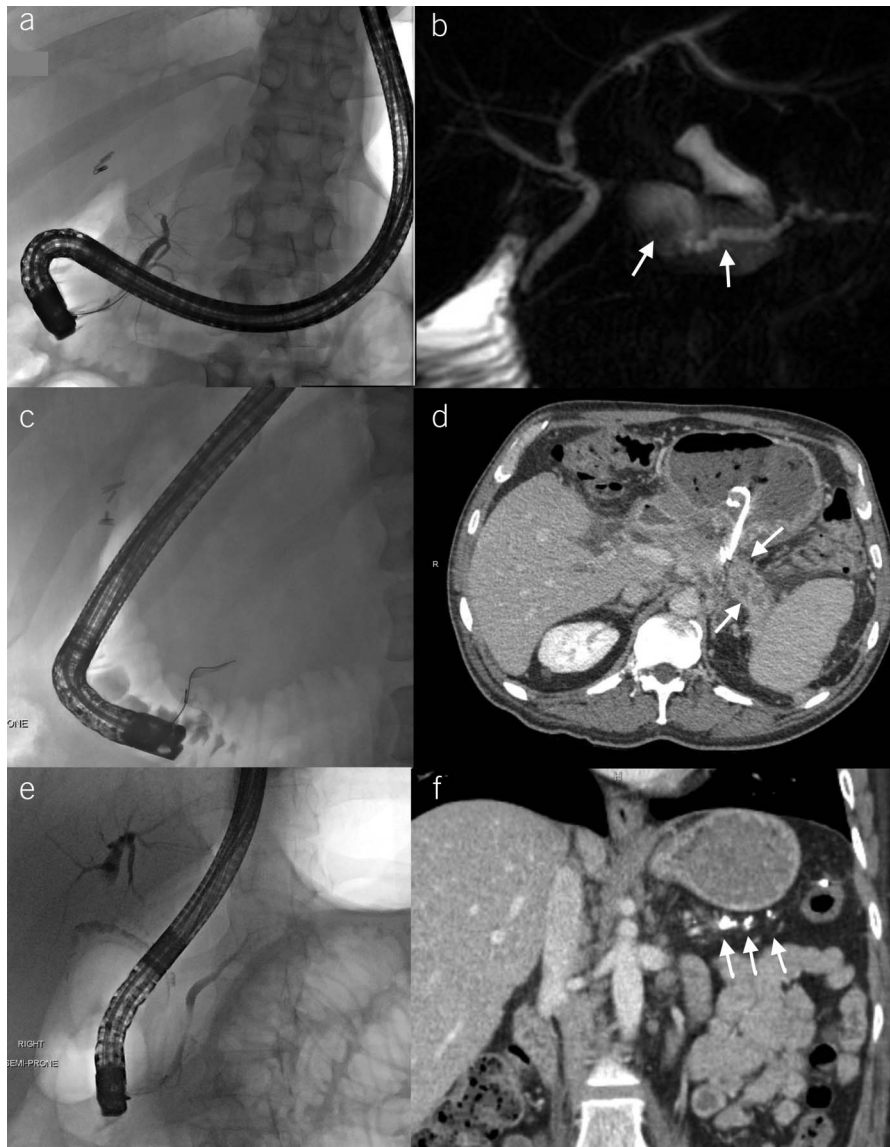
(a and b) ERCP and MRCP demonstrating a recurrent peripancreatic fluid collection and a dilated, disconnected pancreatic duct. (c and d): ERCP and CT demonstrating a disconnected pancreatic segment with surrounding peripancreatic fat stranding and inflammatory changes consistent with acute pancreatitis. Cystogastrostomy plastic stents are seen adjacent to the disconnected pancreas. (e and f) ERCP and CT demonstrating calculi in the main duct and side branches consistent with chronic calcific pancreatitis of the disconnected pancreatic segment with sparing of the pancreatic duct in the head and neck. CT, computed tomography; ERCP, endoscopic retrograde cholangiopancreatography; MRCP, magnetic resonance cholangiopancreatography.
